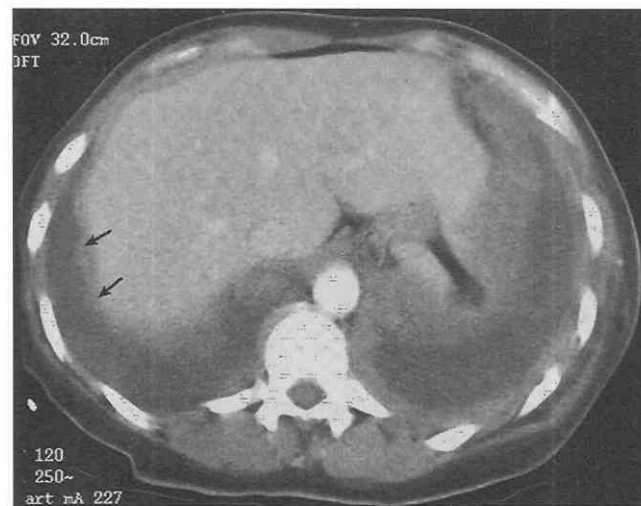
CT scan of the "interface" sign. The interface between the pleural effusion and liver laterally is hazy (arrows). A sharp interface would exist between ascites and the liver.
